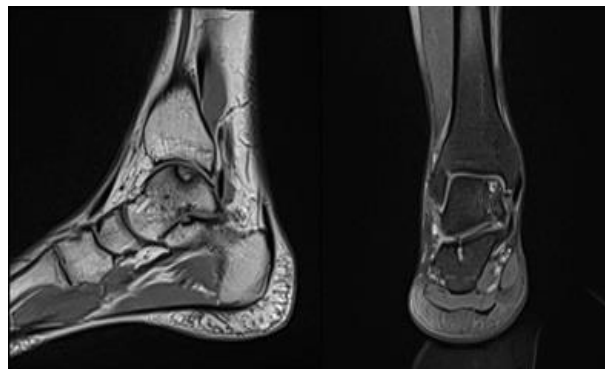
Preoperative MR images of a patient with osteochondral defect in the talus
